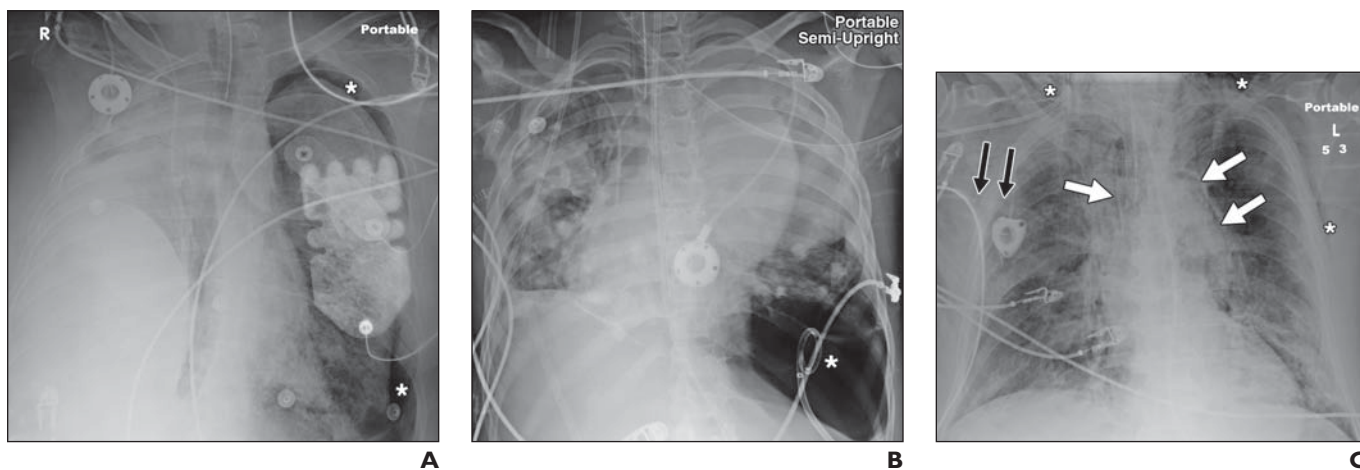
Barotrauma in three patients. A, 61-year-old woman with metastatic lung cancer, pneumonia, and large loculated right pleural effusion. Anteroposterior chest radiograph performed after endotracheal intubation shows development of left pneumothorax (*asterisks*). External pacemaker-defibrillator electrode plates are seen overlying left hemithorax. B, 11-year-old girl with metastatic osteosarcoma. Anteroposterior chest radiograph shows left tension pneumothorax after endotracheal intubation. Intrapleural air is collecting at left lung base (*asterisk*), expanding costophrenic sulcus (deep sulcus sign). There is rightward shift of mediastinum. Bilateral pulmonary nodules and left pleural masses represent metastatic disease, and bilateral diffuse airspace disease corresponds to superimposed pneumonia. C, 69-year-old man. Anteroposterior chest radiograph shows development of pneumomediastinum (*white arrows*) and extensive subcutaneous (*asterisks*) and intramuscular (*black arrows*) emphysema after endotracheal intubation.
